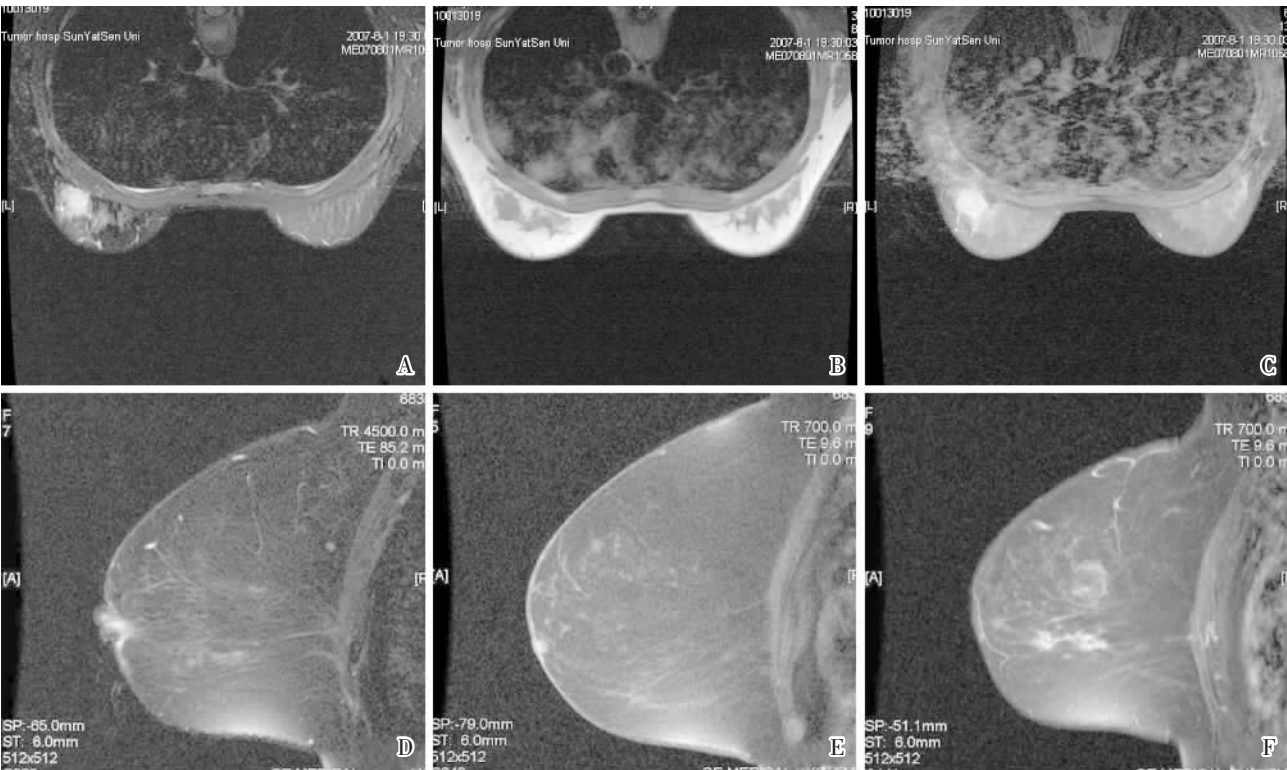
Plain and contrast-enhanced MR images of the breast
